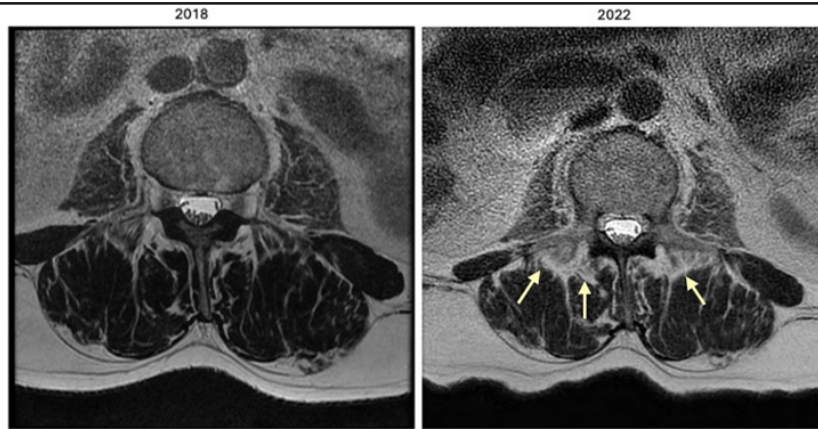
Paraspinal muscle MRI images. MRI images from 2018 and 2022 demonstrating progressive fatty infiltration of the paraspinal and posterior pelvic muscles. The 2022 image (yellow arrows) highlights areas consistent with fatty replacement, which is markedly more prominent compared to the 2018 baseline.
